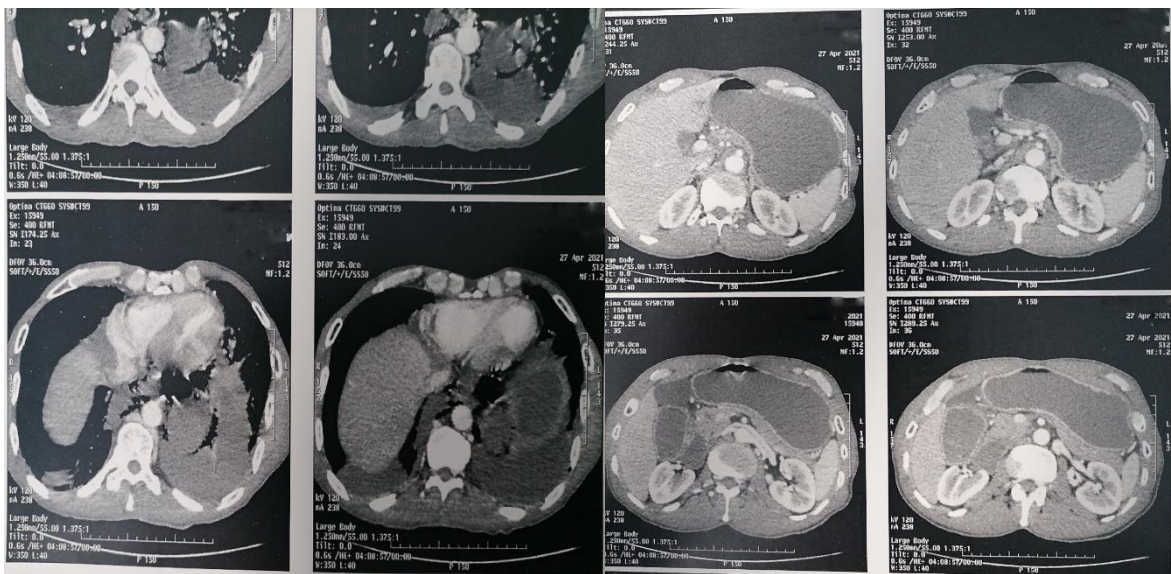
Sections of thoracoabdominal CT scan
